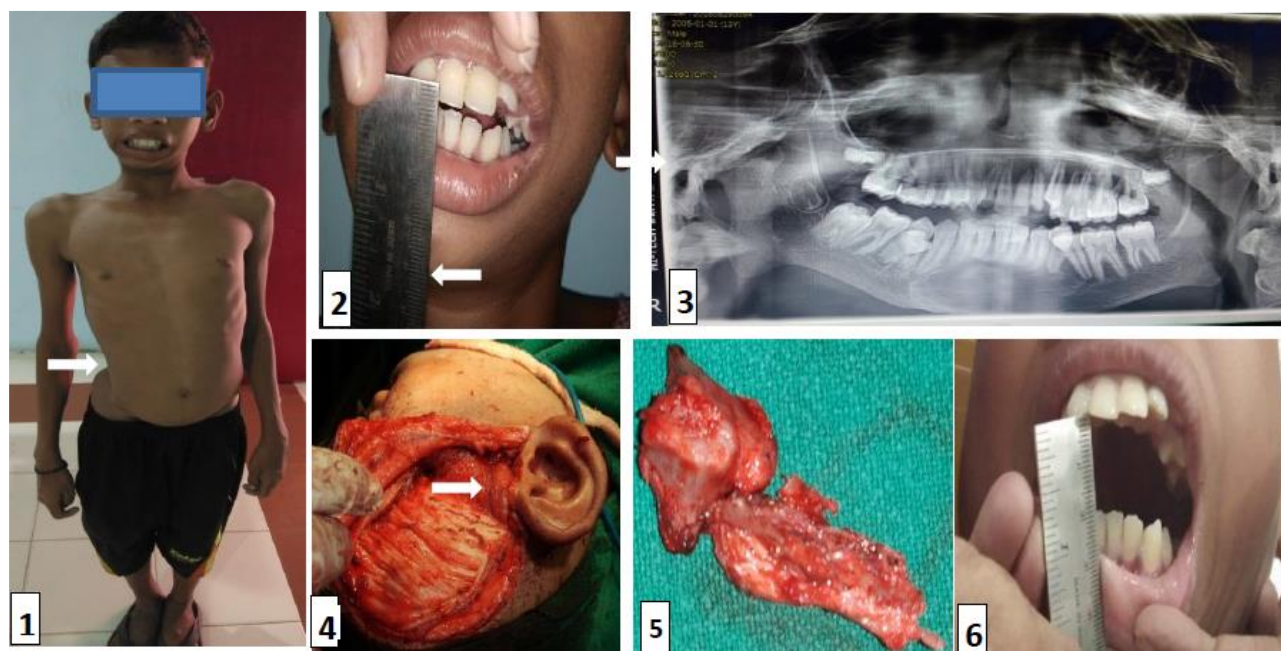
Kyphoscoliosis condition (arrow), Fig 2: Deviated chin to ipsilateral to TMJ ankylosis and Initial MIO < 3mm (arrow), Fig 3: Orthopantomogram showing TMJ ankylosis (arrow), Fig 4: Temporalis muscle interpositional arthroplasty (arrow), Fig 5: Ankylosed mass excised, Fig 6: MIO > 20mm during follow up months.
